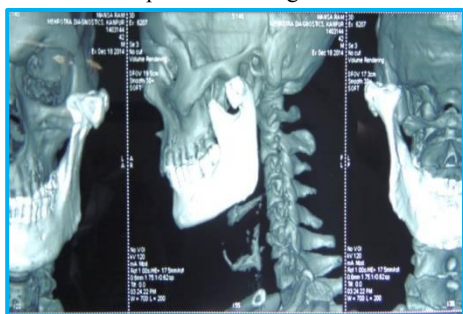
3-D CT showing extension of tumore on lateral and superior
